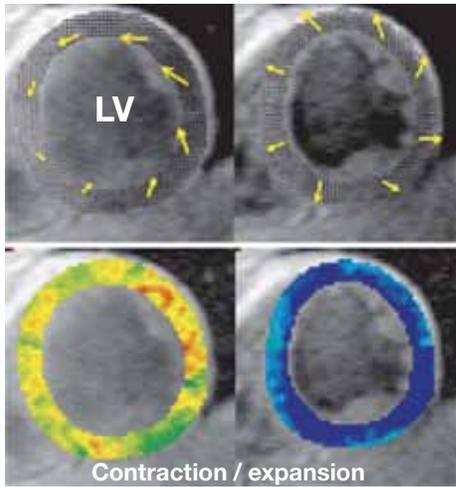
MRI images of left ventricular myocardial motion and interpretation. From: Jung B, Markl M, Föll D, Hennig J. Investigating myocardial motion by MRI using tissue phase mapping. *Eur J Cardiothorac Surg.* 2006;29 Suppl 1:S150-7.
